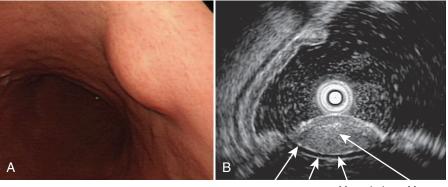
Gastric lipoma. A, Endoscopic view of a slightly elevated lesion covered with normal mucosa. B, Endosonogram showing a homogeneous, hyperechoic mass with smooth borders within the third gastric wall layer.
